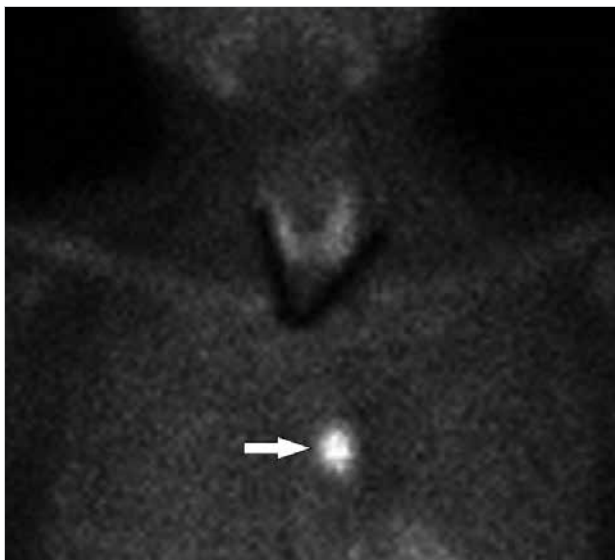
Mediastinal parathyroid adenoma MIBI scintigraphy image
